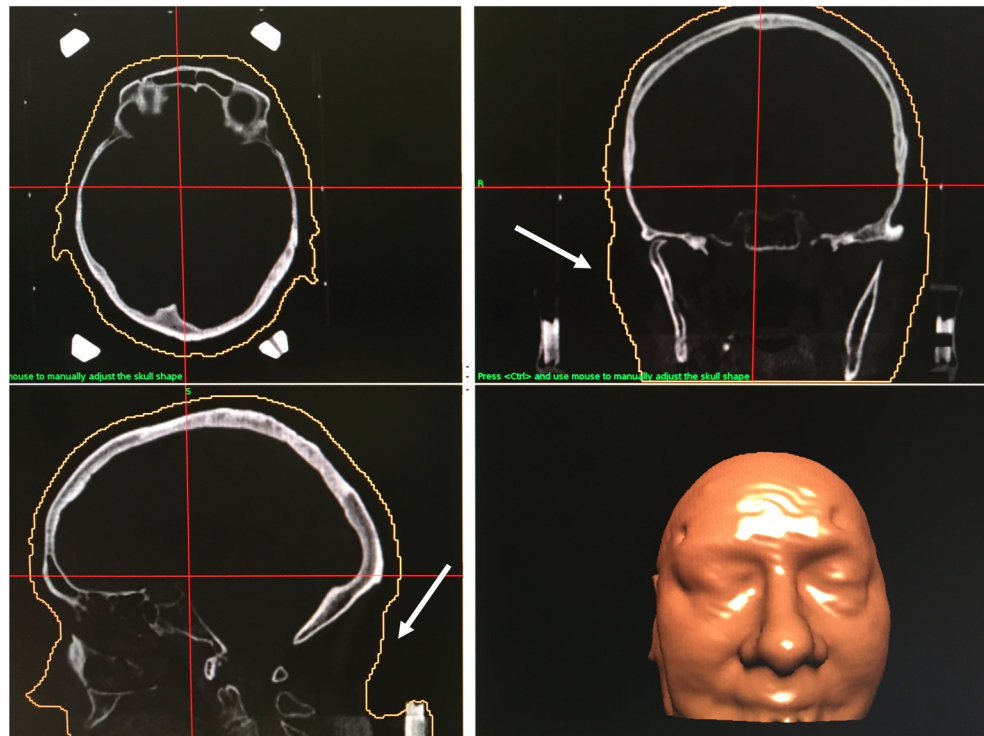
Same patient as in Fig. 1. CT-scan segmentation was used to obtain the skull contour definition. In this process, no measurement is needed. The user is just asked if he agree with the generated volume from the CT scan of the patient. The white arrows point the inferior part of the skull contour definition, which fits with the soft tissue limits
